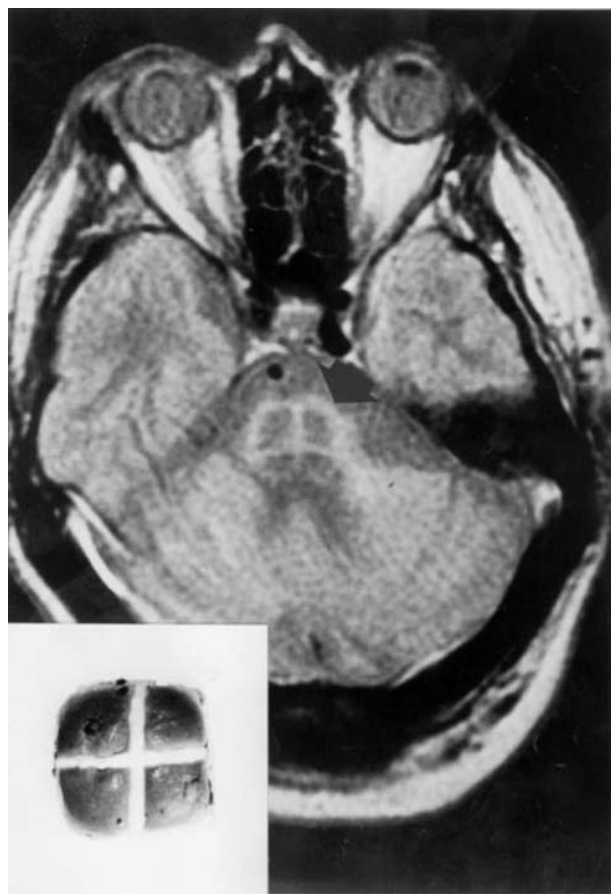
Hot-cross bun sign. Reproduced from Schrag et al. (1998) Clinical usefulness of magnetic resonance imaging in multiple system atrophy. *Journal of Neurology, Neurosurgery and Psychiatry* 65: 65–71, with permission from Journal of Neurology, Neurosurgery and Psychiatry.
